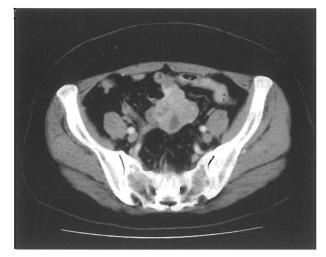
Contrast-enhanced abdominal CT shows hypervascular tumors of the jejunum located in the lower abdomen
